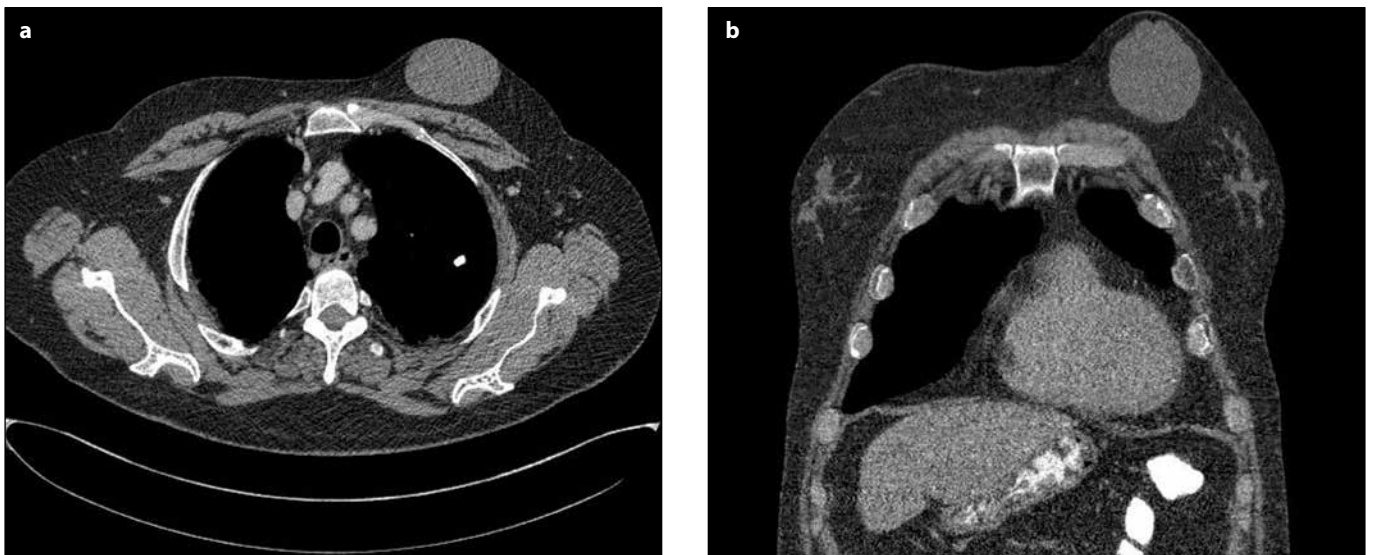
a) Axial CT scan (mediastinal window level) reveals a well-demarcated, homogeneous solid mass lesion in the left breast. b) Coronally reformatted image shows bilateral gynecomastia and the lump in the same section.
